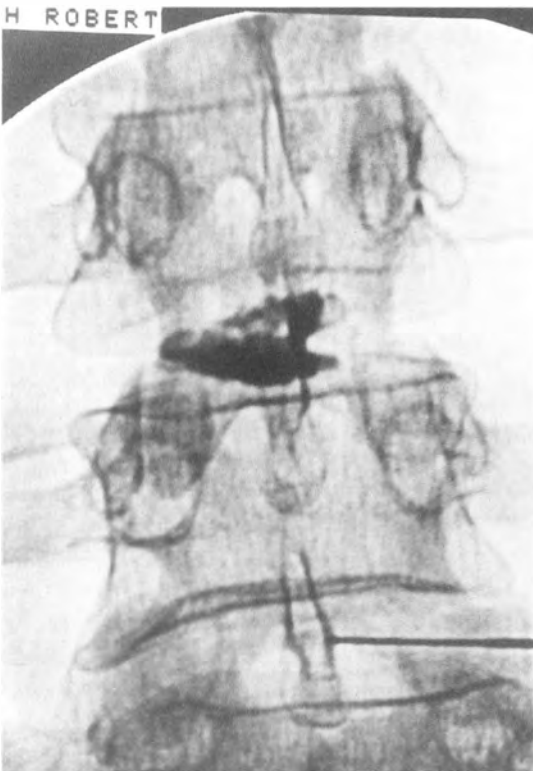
A and B. Type VII: internal disc disruption. (Reprinted with permission from Bernard T. Lumbar discography followed by computed tomography: Refining the diagnosis of low back pain. *Spine* 1990;15(7):690-707.)
